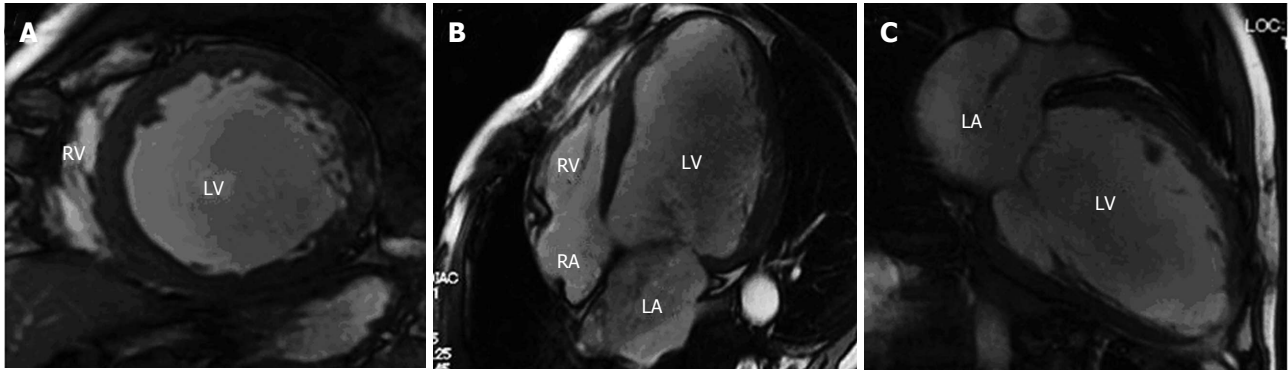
Representative cine-cardiac magnetic resonance images in a 62-year-old male patient with dilated cardiomyopathy. The images show mid-ventricular short axis (A), horizontal axis (4-chambers) (B) and vertical long axis views (C). The images reveal dilatation of left ventricular (LV) cavity and diffuse wall thinning (relatively homogenous). The LV end-diastolic volume, LV end-systolic volume, LV ejection fraction (EF) and LV mass are 329.1 mL, 252.5 mL, and 23.3%, 153.2 g, respectively. LV and RV: Left and right ventricles; LA and RA: Left and right atria; LV: Left ventricular.
